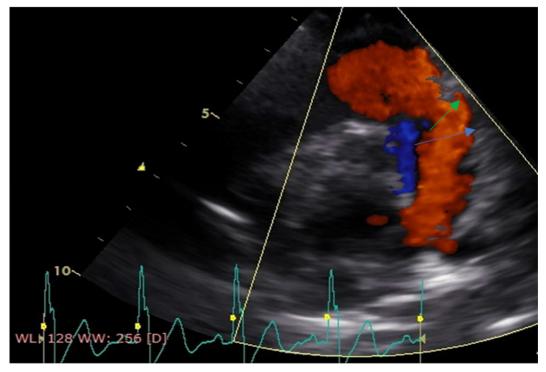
The figure shows parasternal short axis view at the level of PA with color Doppler flow of the PA showing diastolic flow reversal of the PR with the green arrow represents the measurement of the PR jet width and the blue arrow represents the measurement of the PV annulus.
